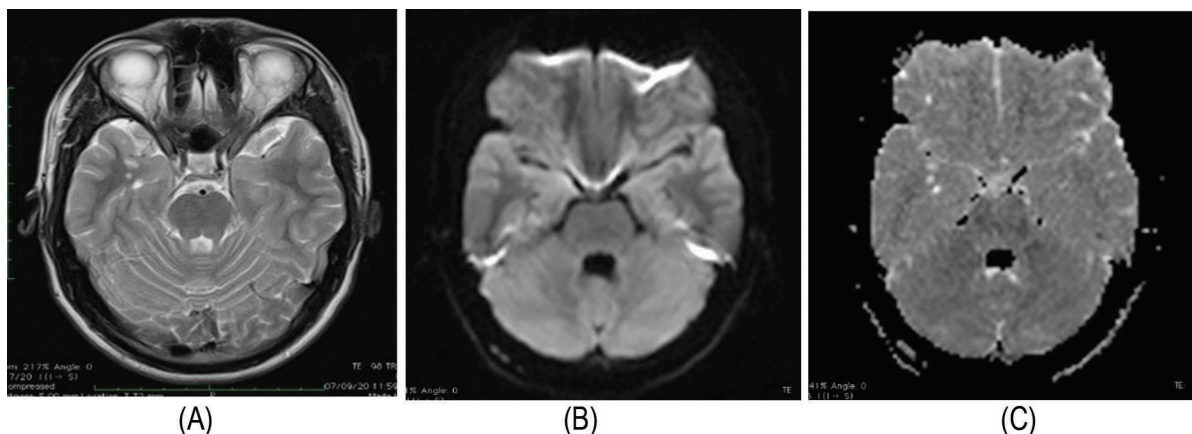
Axial T2W image of epilepsy showing hyperintensity in right medial temporal (A), DWI image (B) & On ADC (C)
